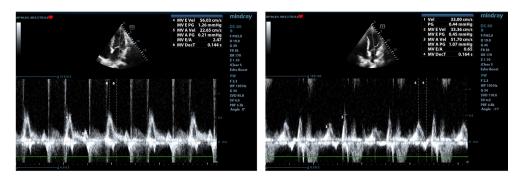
Figure nr. a.2.10. Very good evolution of a severe diastolic dysfunction in a patient with anterior myocardial infarction and depressed LV contractility (LVEF 15%). Left: initial evaluation indicated type 3 of diastolic dysfunction (E=56 cm/s, A=22 cm/s, E/A=2.47, DT=144 ms). Right: after 6 month of follow-up the patient had type 1 of diastolic dysfunction (E=33 cm/s, A=51 cm/s, E/A=0.65, DT=164 ms) (PW Doppler, apical 4-chambers view).
